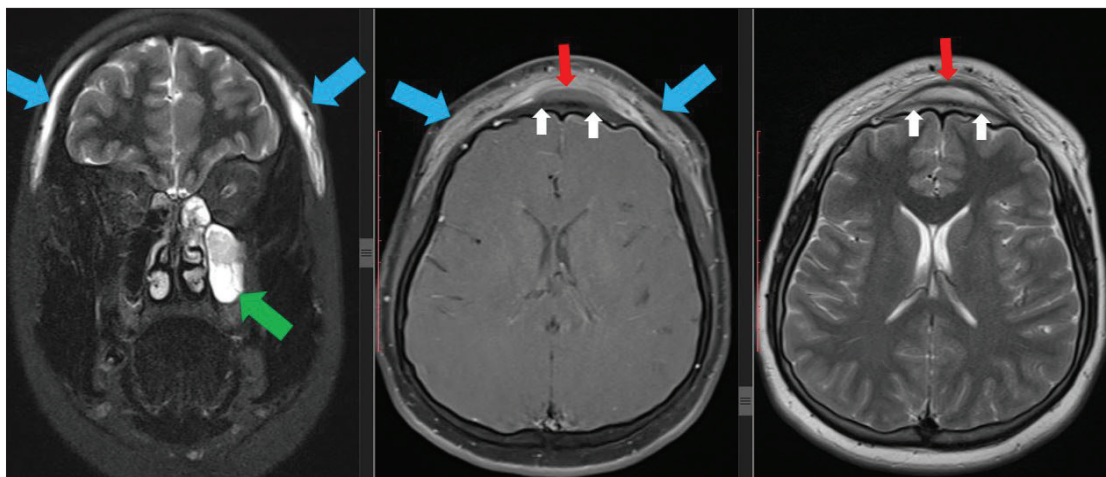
Sections of coronal magnetic resonance imaging fat-suppressed T2, and axial contrast enhanced fat-suppressed T1 and T2 weighted from left to right.
